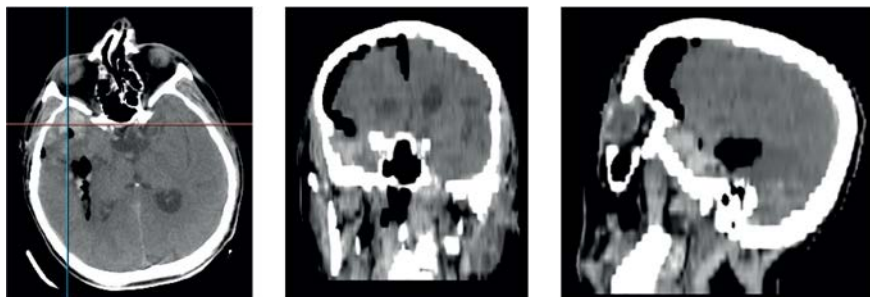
Brain computed tomography of patient R., 47 years old, after surgery
